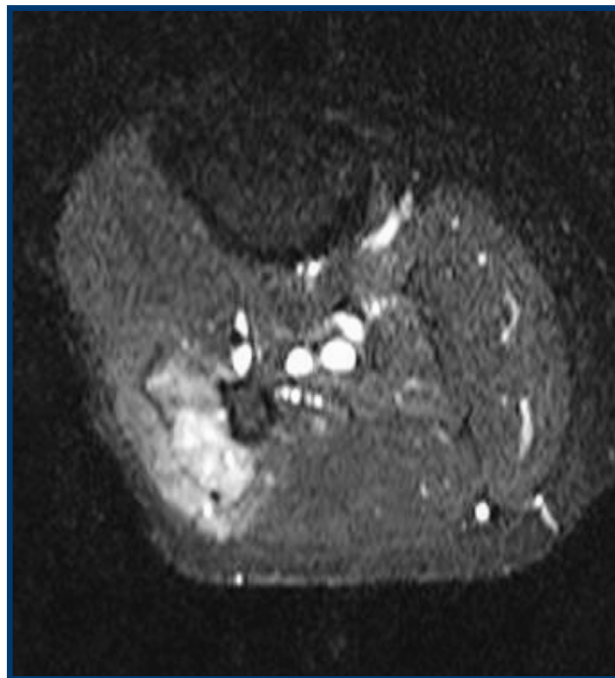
MRI of the right leg. Non-tension edema is seen in the peroneal compartment.
